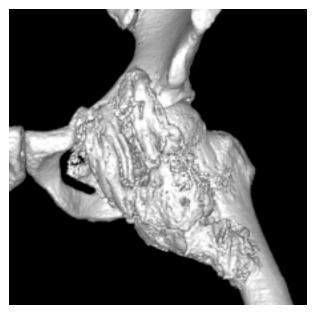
3D CT reconstruction demonstrating heterotopic ossification of the hip.
